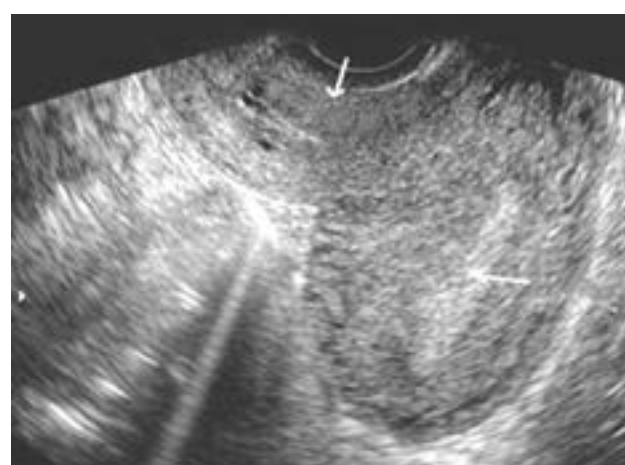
Woman with retroverted anteflexed uterus. Ultrasound image shows cervix angled posteriorly and fundus is angled anteriorly
